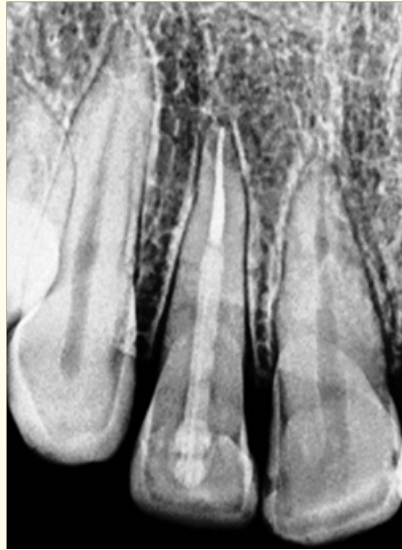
Follow up radiograph after 2 years.
